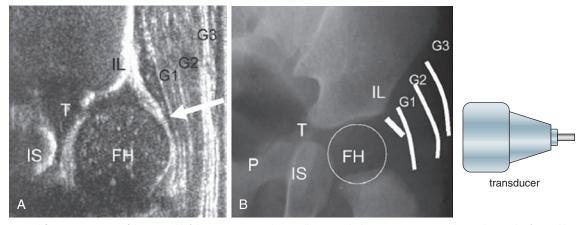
The coronal flexion sonogram of the normal left hip (A) is oriented vertically to match the anteroposterior radiograph (B). The femoral head (FH) is well seated within a nicely rounded acetabulum. The triradiate (T) cartilage, also known as the Y cartilage, is clearly seen between the iliac (IL), public (P), and ischial (IS) bones. The *arrow* on the sonogram points to the fibrous tip of the cartilaginous labrum. G1 refers to the gluteus minimus muscle, G2 to the gluteus medius muscle, and G3 to the gluteus maximus muscle. (*Modified from Smergel E, Losik SB, Rosenberg HK: Sonography of hip dysplasia*, Ultrasound Q 20:201-216, 2004.)
